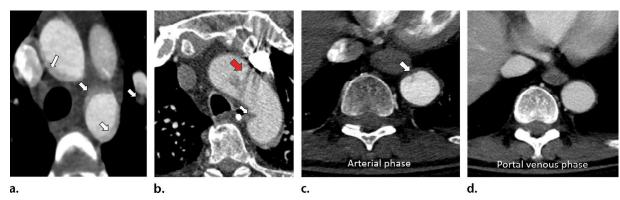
Technical mimics of MAI. (a) Axial multidetector CT image shows motion artifact (arrows) due to cardiac or respiratory motion, which is often obvious due to extension of the artifact beyond the aortic walls or blurred margins of pulmonary vessels or interstitium (not shown). (b) Axial multidetector CT image shows streak artifact (red arrow) from attenuating intravenous contrast material within the left brachiocephalic vein. Note the typical attachment of the ligamentum arteriosum at the medial side of the aortic isthmus (white arrow). (c) Axial arterial phase multidetector CT image demonstrates mixing artifact (arrow). (d) Axial portal venous phase multidetector CT image obtained through the abdomen during the same examination shows that the mixing artifact has been completely resolved.
